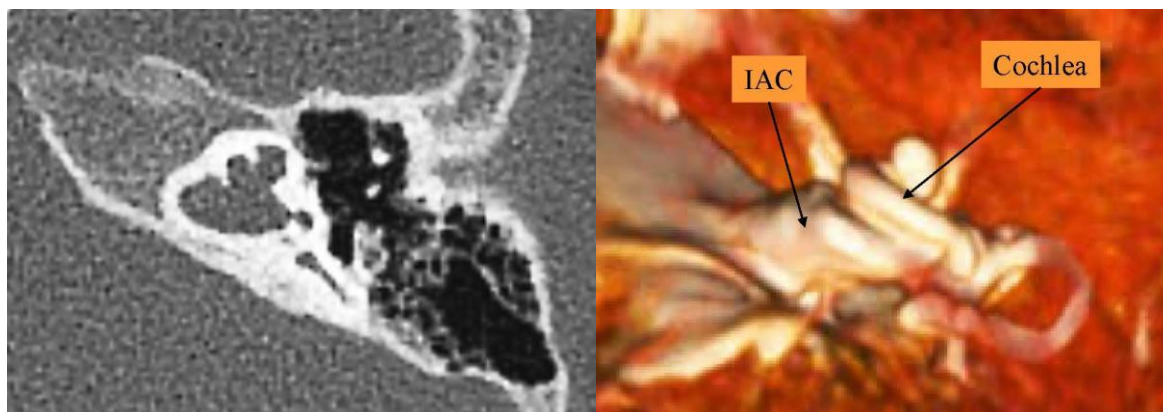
X-linked malformation of the inner ear. Axial CT image demonstrating a cystic malformation with modiolar aplasia (left image) and 3D-reconstruction of an MRI (right image) with the perilymphatic space colored white demonstrating an abnormal cork screw appearance of the cochlea and a very wide internal auditory canal (IAC). Courtesy of Babak Falahat, DDS, Karolinska University Hospital
